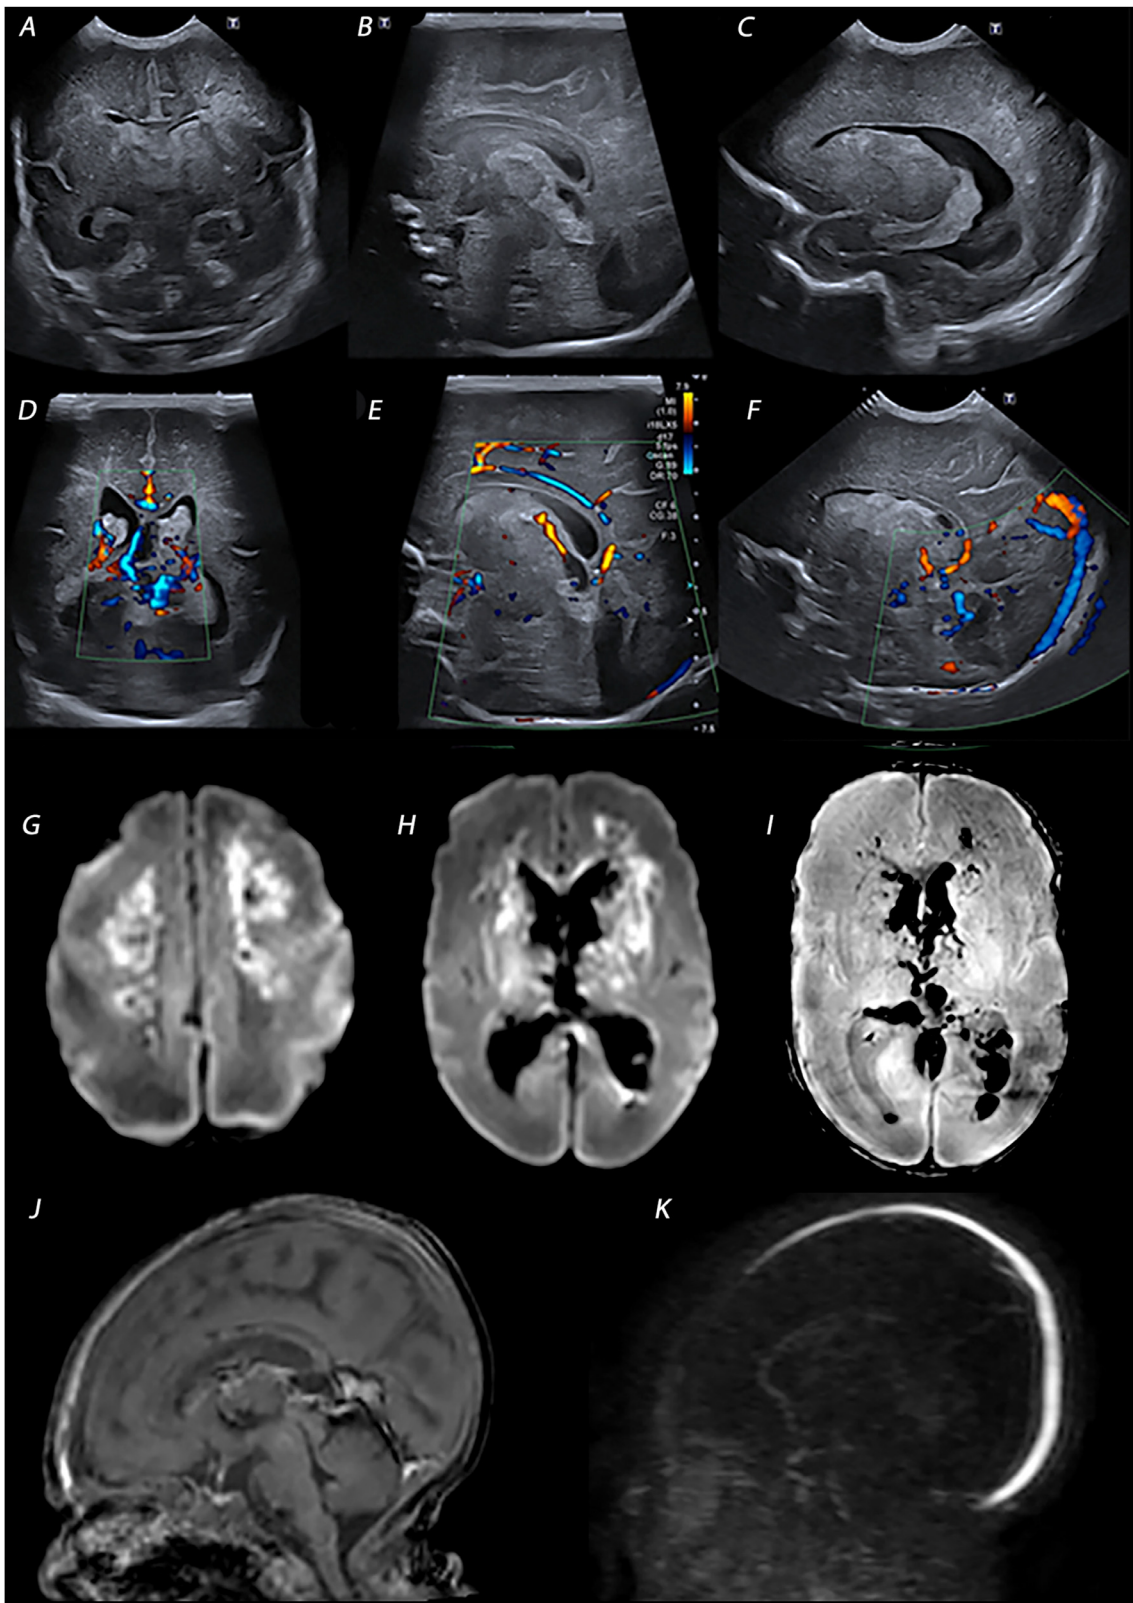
Preterm infant, born at 26 weeks' gestation with multiple sinus thrombosis. Anterior fontanel ultrasound images obtained 5 weeks after birth (31 weeks' gestation) after sudden clinical deterioration showing bilateral intraventricular hemorrhages, inhomogeneous periventricular white matter, and increased echogenicity in the trajectory of the straight sinus (ST) (A-C). Color Doppler ultrasound images demonstrate absence of flow in the left ICV (D) and ST (E-F). MRI images (G-K) were performed the following day. (G-H) Diffusion weighted MR images demonstrating extensive diffusion restriction in the periventricular white matter and deep gray matter. Susceptibility weighted MR image demonstrating the bilateral intraventricular hemorrhages and smaller areas of hemorrhagic infarction in the frontal lobes. (J-K) Midsagittal MRI images, T1-weighted image demonstrating a clot in the straight sinus (J) and MR venography demonstrating absence of flow in the deep venous system (K).
